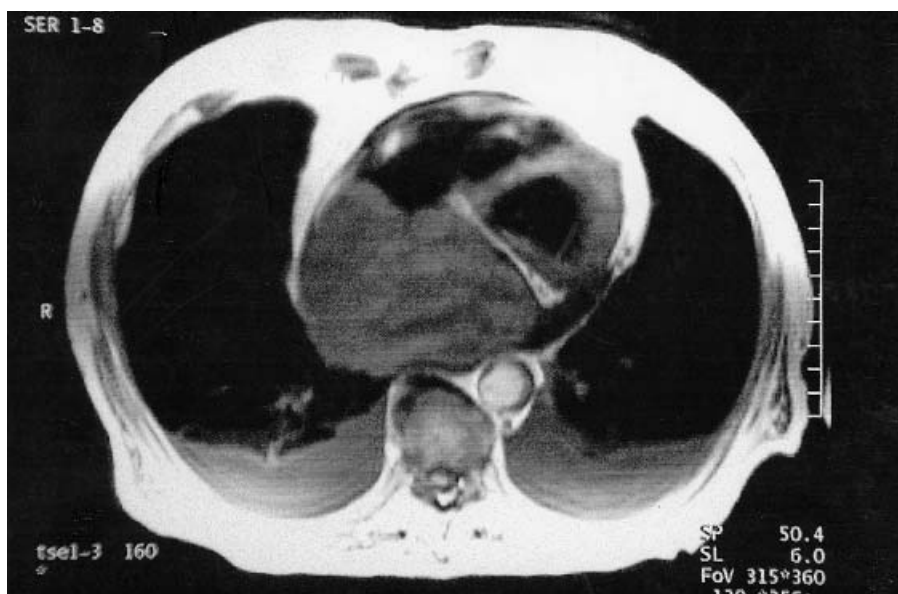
Computed tomography of the chest shows a large atrial tumor occupying both atria.
